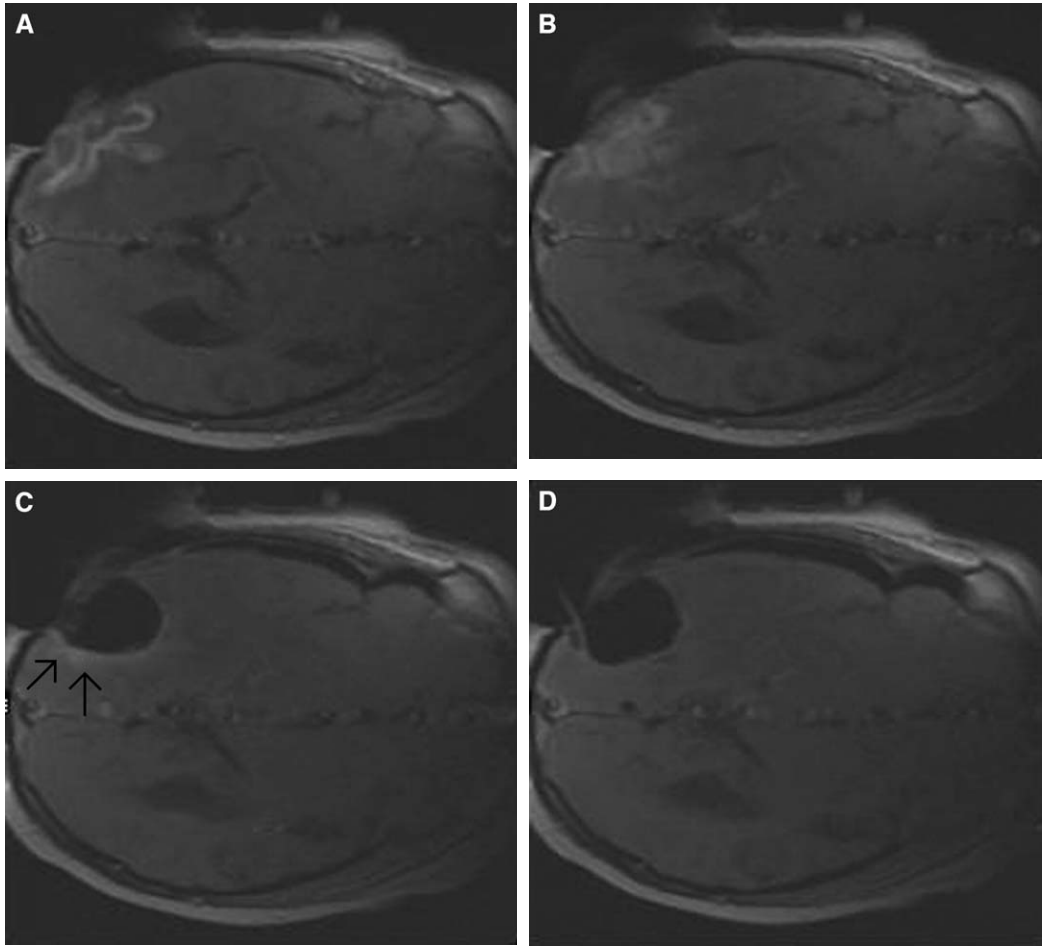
(A) Intraoperative image of glioma before the start of resection. (B) Updated image after some resection. (C) Near-complete resection. Note residual tumor (*arrows*) that could have been missed without the aid of intraoperative MRI. (D) Complete resection.
